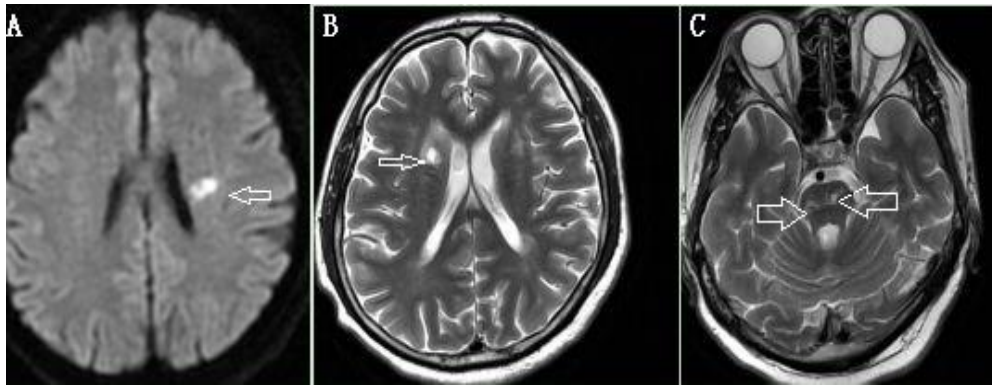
The DWI findings acute infarct in the left corona radiata(A,DWI).The MRI T2 also showed multiple lacunar infarcts in the corona radiata and corona pans(B and C, T2-weighted).
